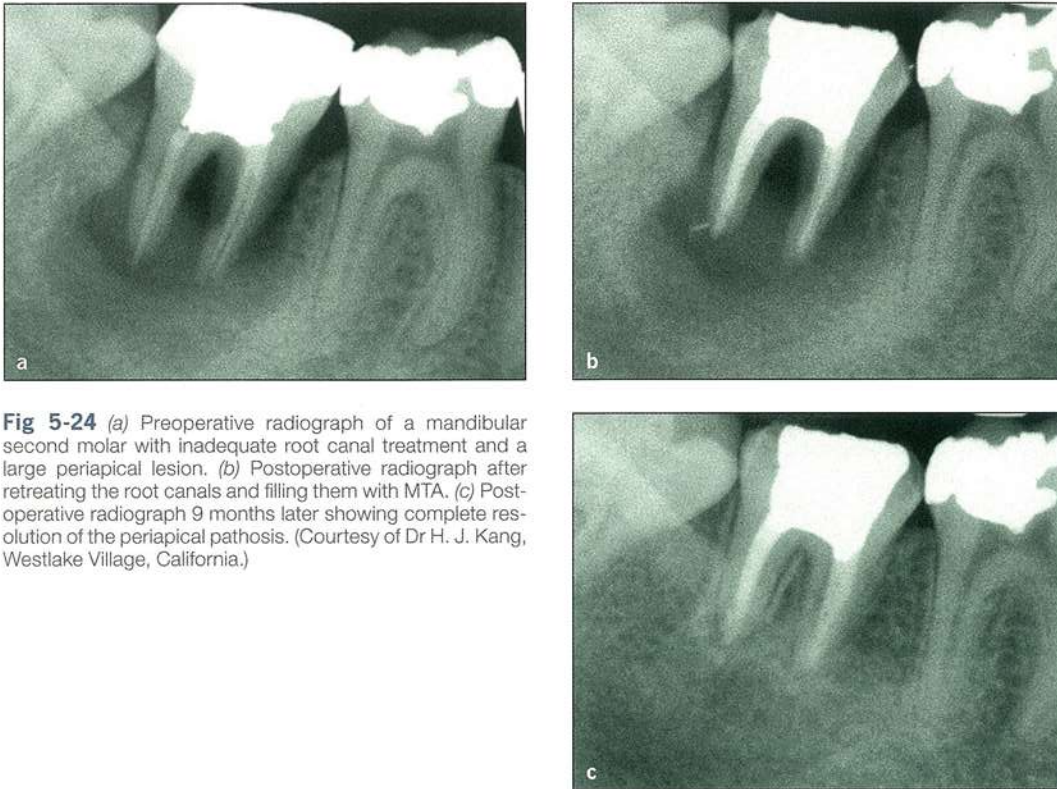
(a) Preoperative radiograph of a mandibular second molar with inadequate root canal treatment and a large periapical lesion. (b) Postoperative radiograph after retreatment of the root canals and filling them with MTA. (c) Postoperative radiograph 9 months later showing complete resolution of the periapical pathosis. (Courtesy of Dr H. J. Kang, Westlake Village, California.)
